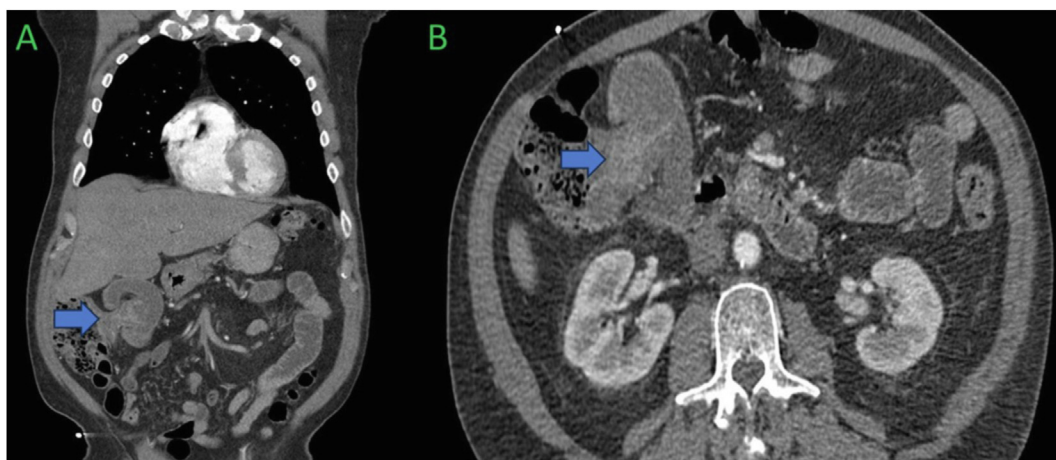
(A) Coronal image of CT abdomen and pelvis with IV contrast showing colo-colonic intussusception (blue arrow). (B) Axial image of CT abdomen and pelvis with IV contrast showing colo-colonic intussusception (blue arrow). CT, computed tomography; IV, intravenous.
